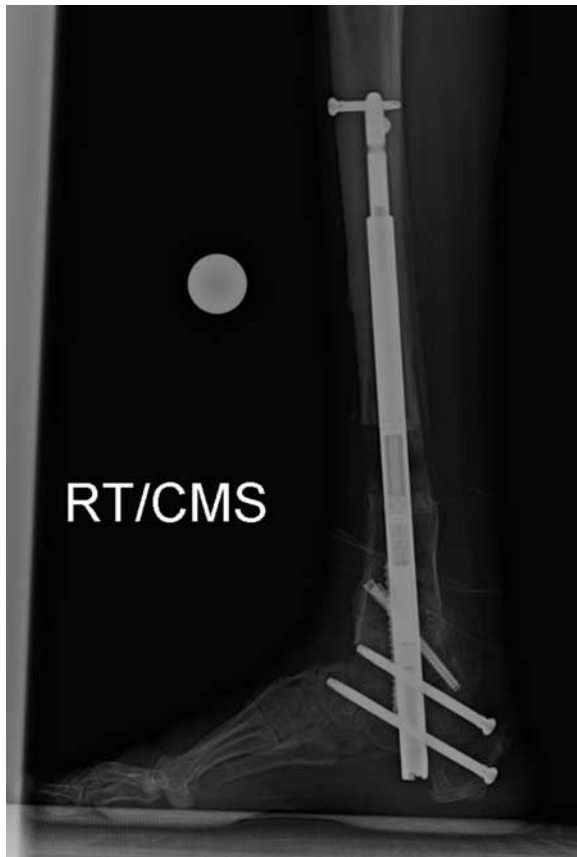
E.C. is a 49-year-old male with sequelae from polio and previous surgeries with a 3.5 cm leg length difference and a painful, stiff varus ankle and hindfoot. He underwent hardware removal, realignment with ankle fusion and retrograde tibia lengthening with a piriformis Stryde implant. He had restricted weight-bearing for 6 weeks until the ankle fusion was healed enough to allow full weight-bearing. This is a lateral x-ray 3 months after surgery with a 2.5 cm lengthening. RT indicates right.
